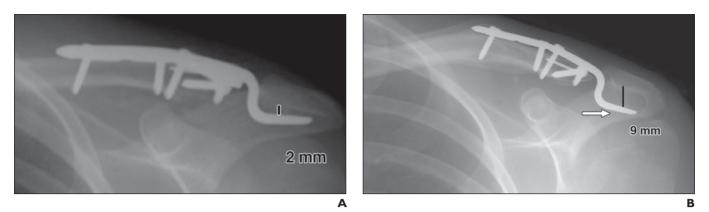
18-year-old man with left clavicle fracture shows normally positioned blade hook clavicle plate fixating comminuted distal third clavicle shaft fracture. A, Initial postoperative anteroposterior radiograph of left clavicle shows normally positioned blade hook clavicle plate fixating comminuted distal third clavicle shaft fracture. Black line shows distance between hook and undersurface of acromion.
